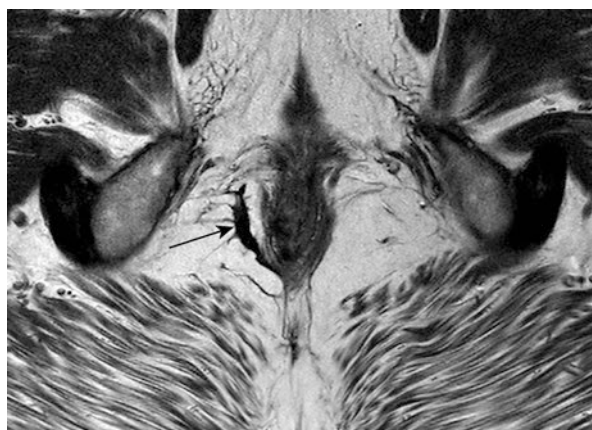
A fistula (*arrow*) with hypointense signal intensity on an oblique coronal T2-weighted sequence (a) and oblique axial T2-weighted fat-suppressed sequence (b) indicates a fibrotic tract (the tract is also hypointense on a T1-weighted contrast-enhanced sequence but this is not shown here)
